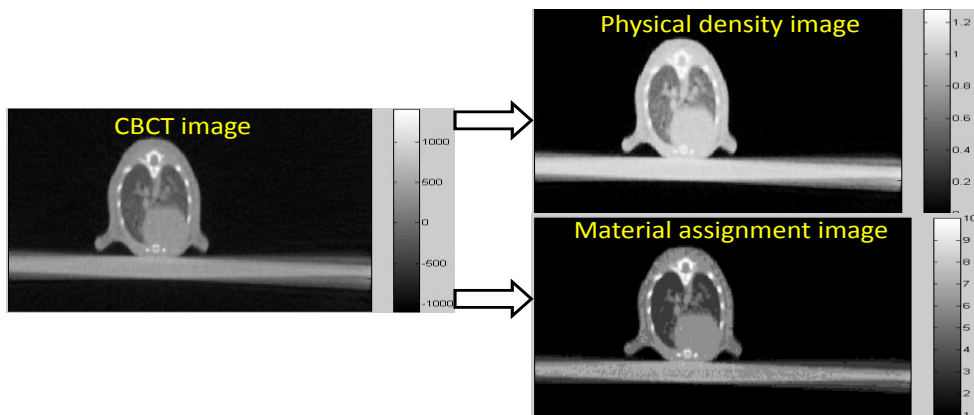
CBCT image conversion to physical density and material image
